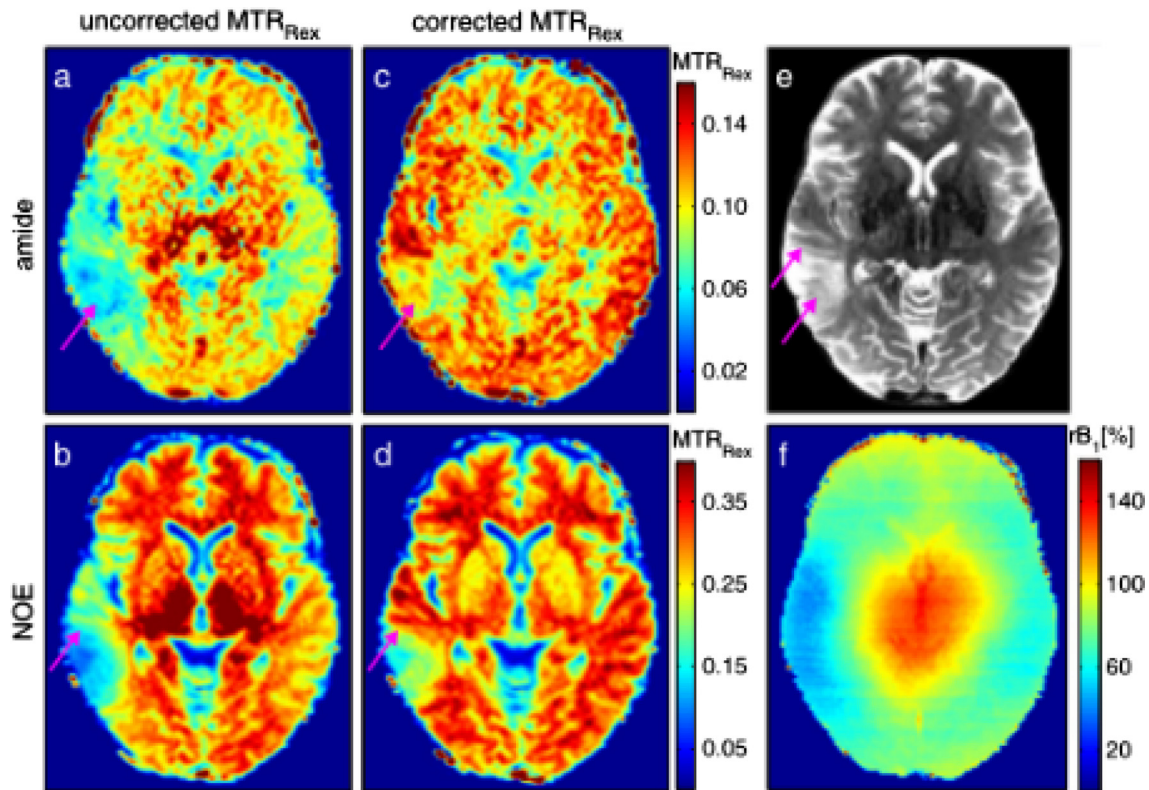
Application of an optimized B_1 correction method to CEST images of a patient with oligodendroglioma WHO grade 2. Uncorrected CEST images based on MTR_{Rex} with nominal $B_1 = 0.9 \mu$ T (a, b) and 2-point B_1 -corrected CEST images based on MTR_{Rex} at $B_1 = 0.8 \mu$ T (c, d) for amides ($\delta_{amide} = 3.5$ ppm) (a, c) and aliphatic NOE ($\delta_{NOE} = -3.5$ ppm) (b, d). T2-weighted image (e) and B_1 field map (f) of the same patient. The pink arrows indicate regions of altered contrast due to B_1 correction. Reproduced with permission from [521]. MTR_{Rex} is the T2- and MT-corrected magnetization transfer ratio defined by $MTR_{Rex} = \frac{M_0}{M_{sat}(\delta\omega_s)} - \frac{M_0}{M_{sat}(\delta\omega_{ref})}$, which is the inverse difference when compared to Eq. (8).
